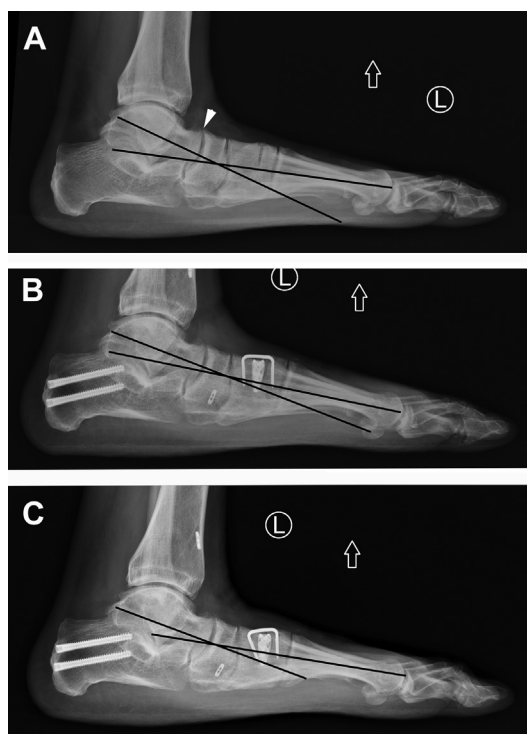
Preoperative lateral radiograph (A) with deformity centered at the level of the NC joint. Note the lack of subluxation of the talonavicular (TN) joint (*white arrowhead*). Three months postoperative (B), mild improvement in the deformity is noted following an MDCO, FDL tendon transfer, spring ligament reconstruction, gastrocnemius recession, and Cotton osteotomy. However, near-complete recurrence of the deformity is noted (C) 6 months post-operatively secondary to continued collapse through the NC joint.
